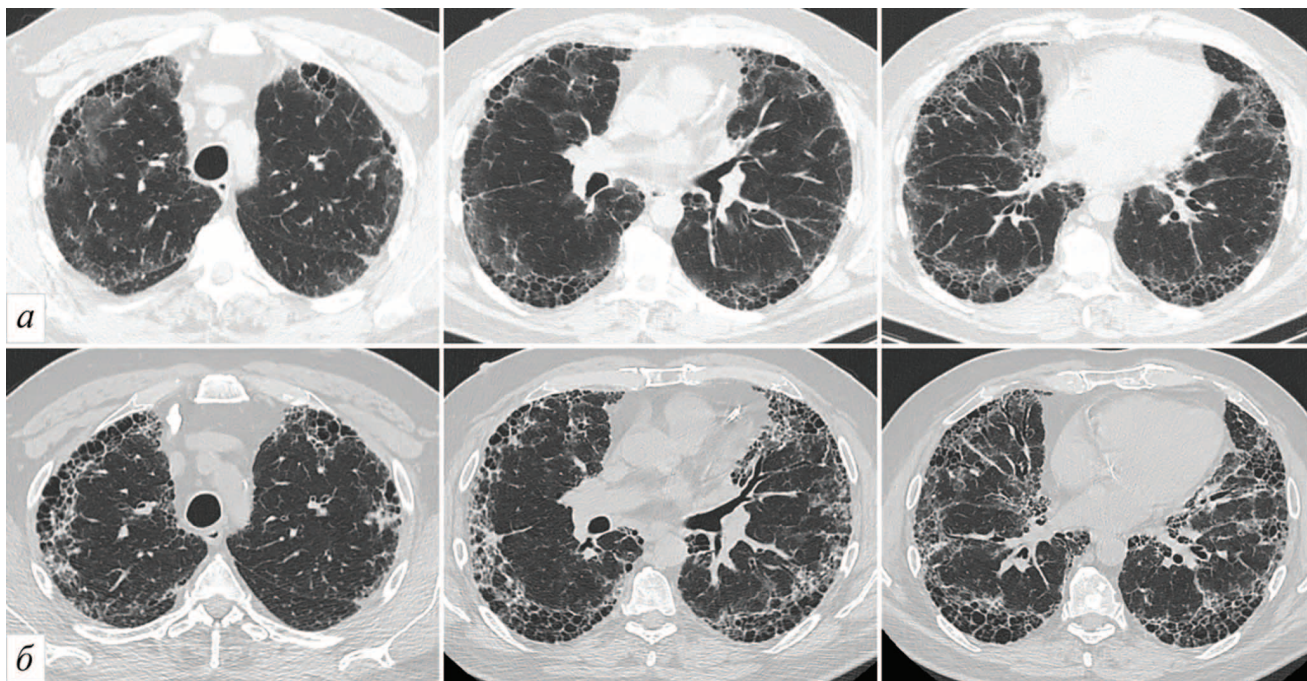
Patient N., 58 years old. COVID-19 (PCR+) on the background of usual interstitial pneumonia. Axial chest CT scans at appropriate levels. Row A — the study dated 07.03.2021, row B — the study dated 21.04.2021. In dynamics, in place of areas of “ground glass” the appearance of pronounced reticular changes and structural realignment in the form of a “honeycomb lung”, the progression of “honeycombs” in the already existing areas, the appearance of their additional rows
